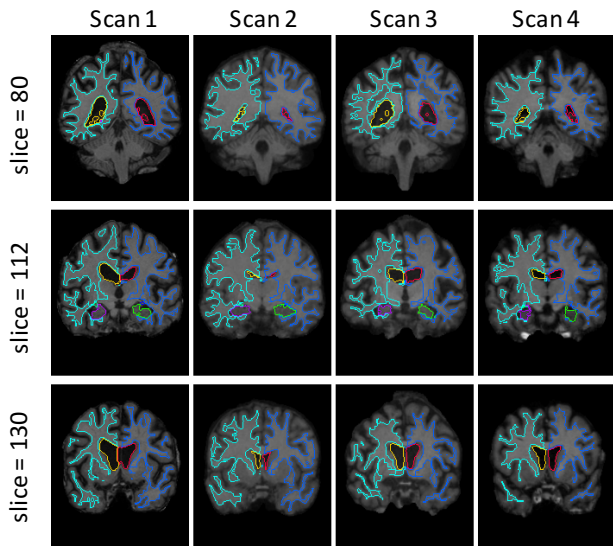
Example coronal slices from the 3D MRI brain dataset, after affine alignment. Each column is a different scan (subject) and each row is a different coronal slice. Several significant anatomical regions are outlined using different colors: L/R white matter in light/dark blue, L/R ventricles in yellow/red, and L/R hippocampi in purple/green. There are significant structural differences across scans, necessitating a deformable registration step to analyze inter-scan variations.
